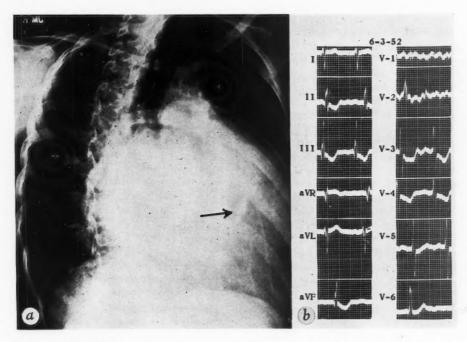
Roentgenogram of the thorax taken in the right anterior oblique position showing the marked enlargement of the heart, particularly the left atrium and right ventricular outflow region, and calcification of the mitral valve (point of arrow).
